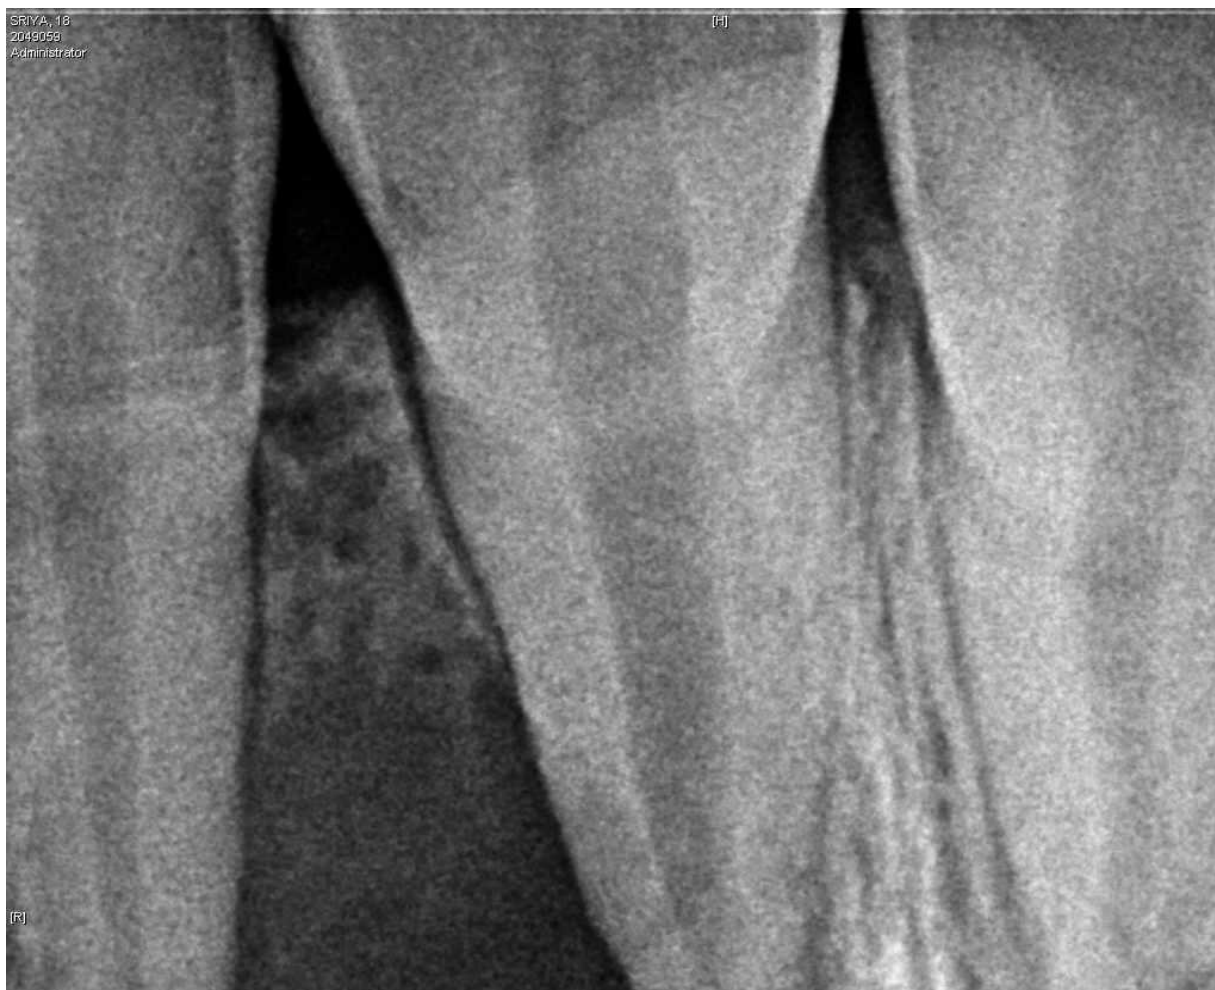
Pre operative radiograph with bone defect
